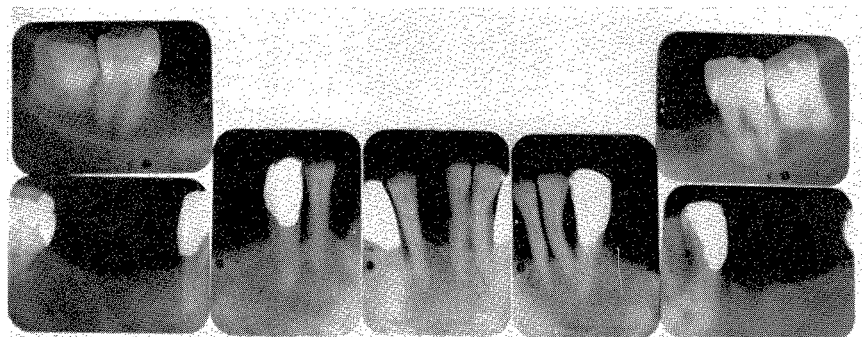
Roentgenograms taken in 1953. There was little or no deterioration during the previous ten years.
